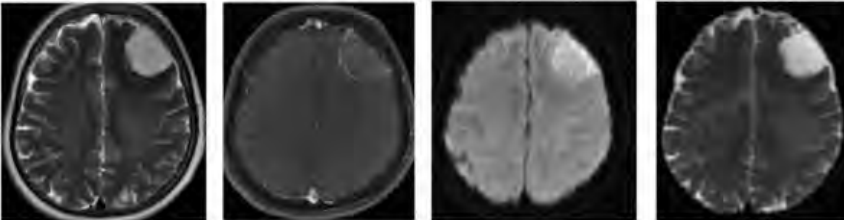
MRI Brain demonstrates T2W hyperintensity (first image), hyperintensity on both DWI and ADC likely due to T2 shine-through phenomenon, and mild heterogeneous contrast enhancement.
